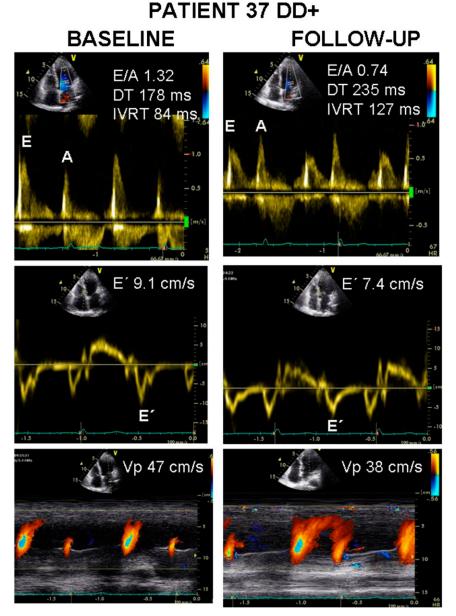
Baseline and follow-up recordings of mitral inflow velocities, pulsed tissue Doppler velocities at the septal mitral annulus, and color M-mode propagation velocity in a patient developing diastolic dysfunction.
